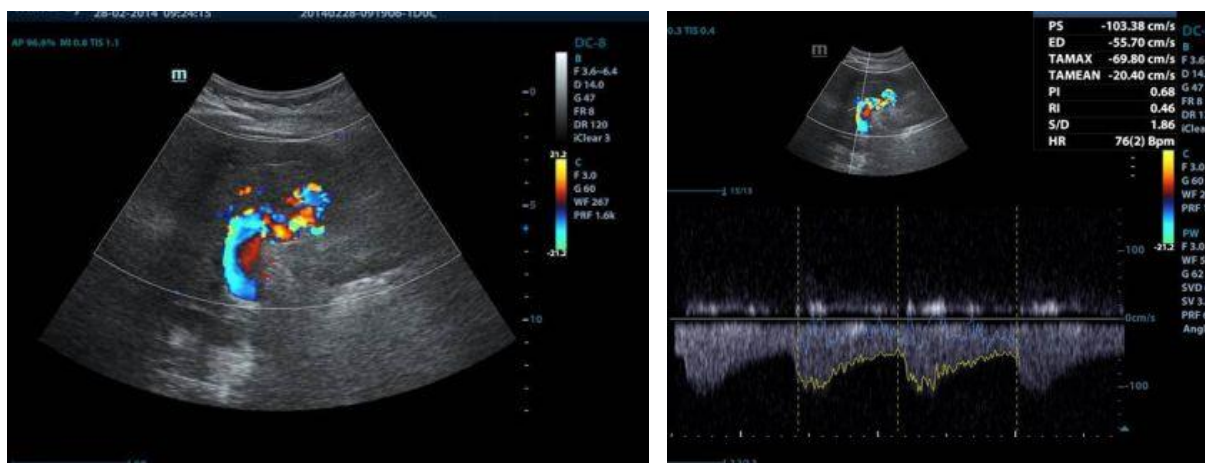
Liver Doppler ultrasound: a) mixed arterial and venous flow in PV; b) hepatofugal PV flow with high velocity arterial waveform in the portal trunk and branches .
